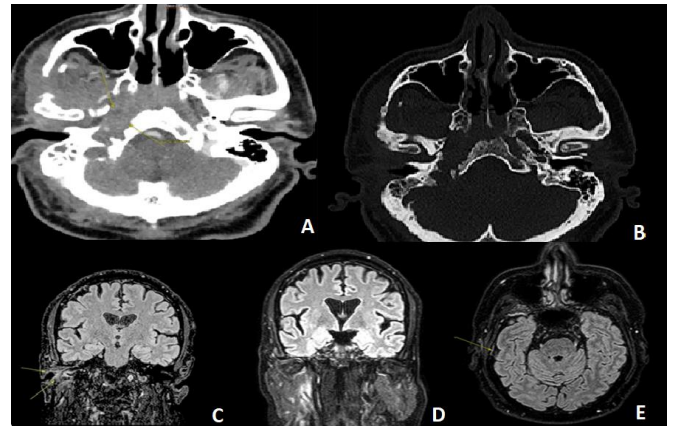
A. CT-scan with contrast agent)- Transverse plane: Pathologic tissue with epicenter at the level of the apex of the right petrous bone, with swelling of the vault of the nasopharynx. Posteriorly medial extension of the right prevertebral and carotid spaces with abscessing of the ICA. Posteriorly extending to the ipsilateral jugular foramen and hypoglossal canal. Infiltration of the right jugular vein appearing filiform; B. CT-scan Tranverse plane: Osteodisgregation of the petrous apex, clivus, and right occipital condyle. Also right tissue component in the right masticatory space. Bony remnant of the right zygomatic arch; C. MRI with contrast agent- Coronal plane. Concentric thickening of the mucosal-submucosal planes along the walls of the external ear canal, with stenosis of its lumen, T2 sequence; D. MRI with contrast agent- Coronal plane. Hypersignal extending: Postero- inferiorly to the insertion of the sternocleidomastoid muscle, anteriorly to the mandibular condyle, laterally and cranially to the temporalis muscle. Caudally, the tissue reaches to affect the deep portion of the ipsilateral parotid gland as far back as the lateral wall of the oropharynx.; E. MRI with contrast agent, Tranverse plane: dural thickening is denoted in the right temporal region
